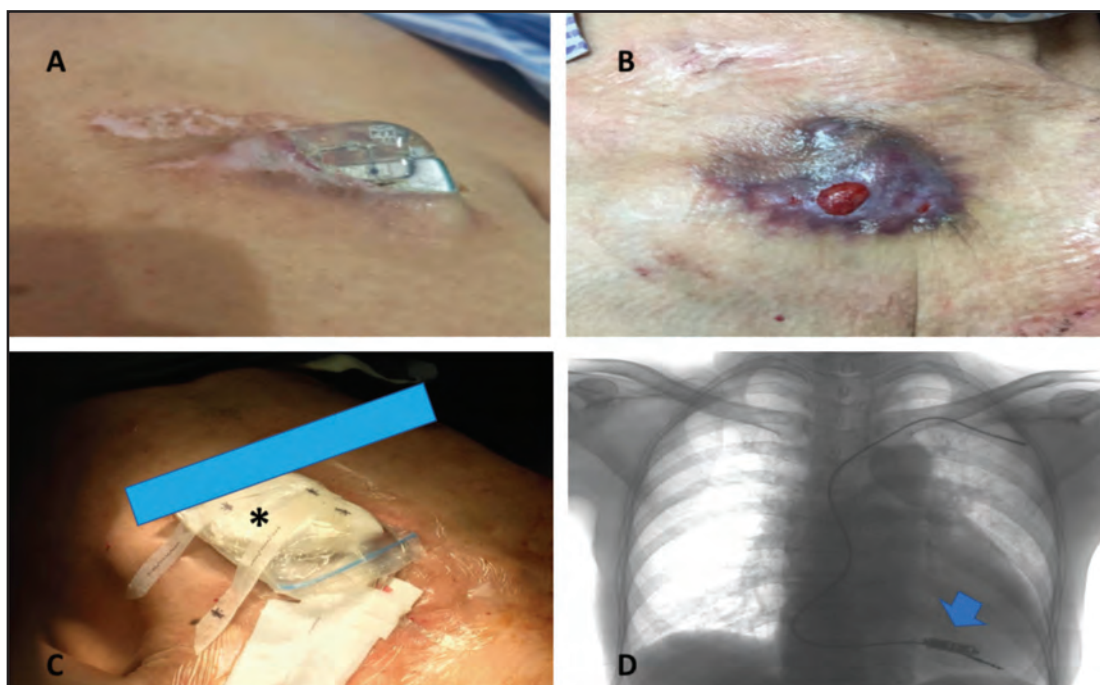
Images of patients' CIED, A; Protrusion of CIED device on left pectoral, B; Unhealthy discoloration and granulation tissue post sub-pectoral implantation, C; CIED (marked *) was secured inside sterile container during second operation, D; Chest X-Ray post Micra™ (Arrow) insertion and extraction of pacemaker, previous lead was left in situ.
